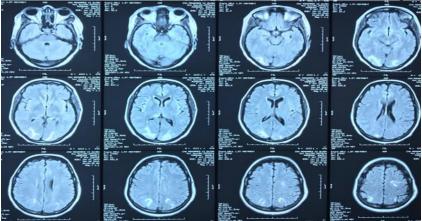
Cerebral MRI: Signal abnormality of the bilateral parieto-occipital and left frontal subcortical white matter in the form of increased T2 and FLAIR signal intensity.
